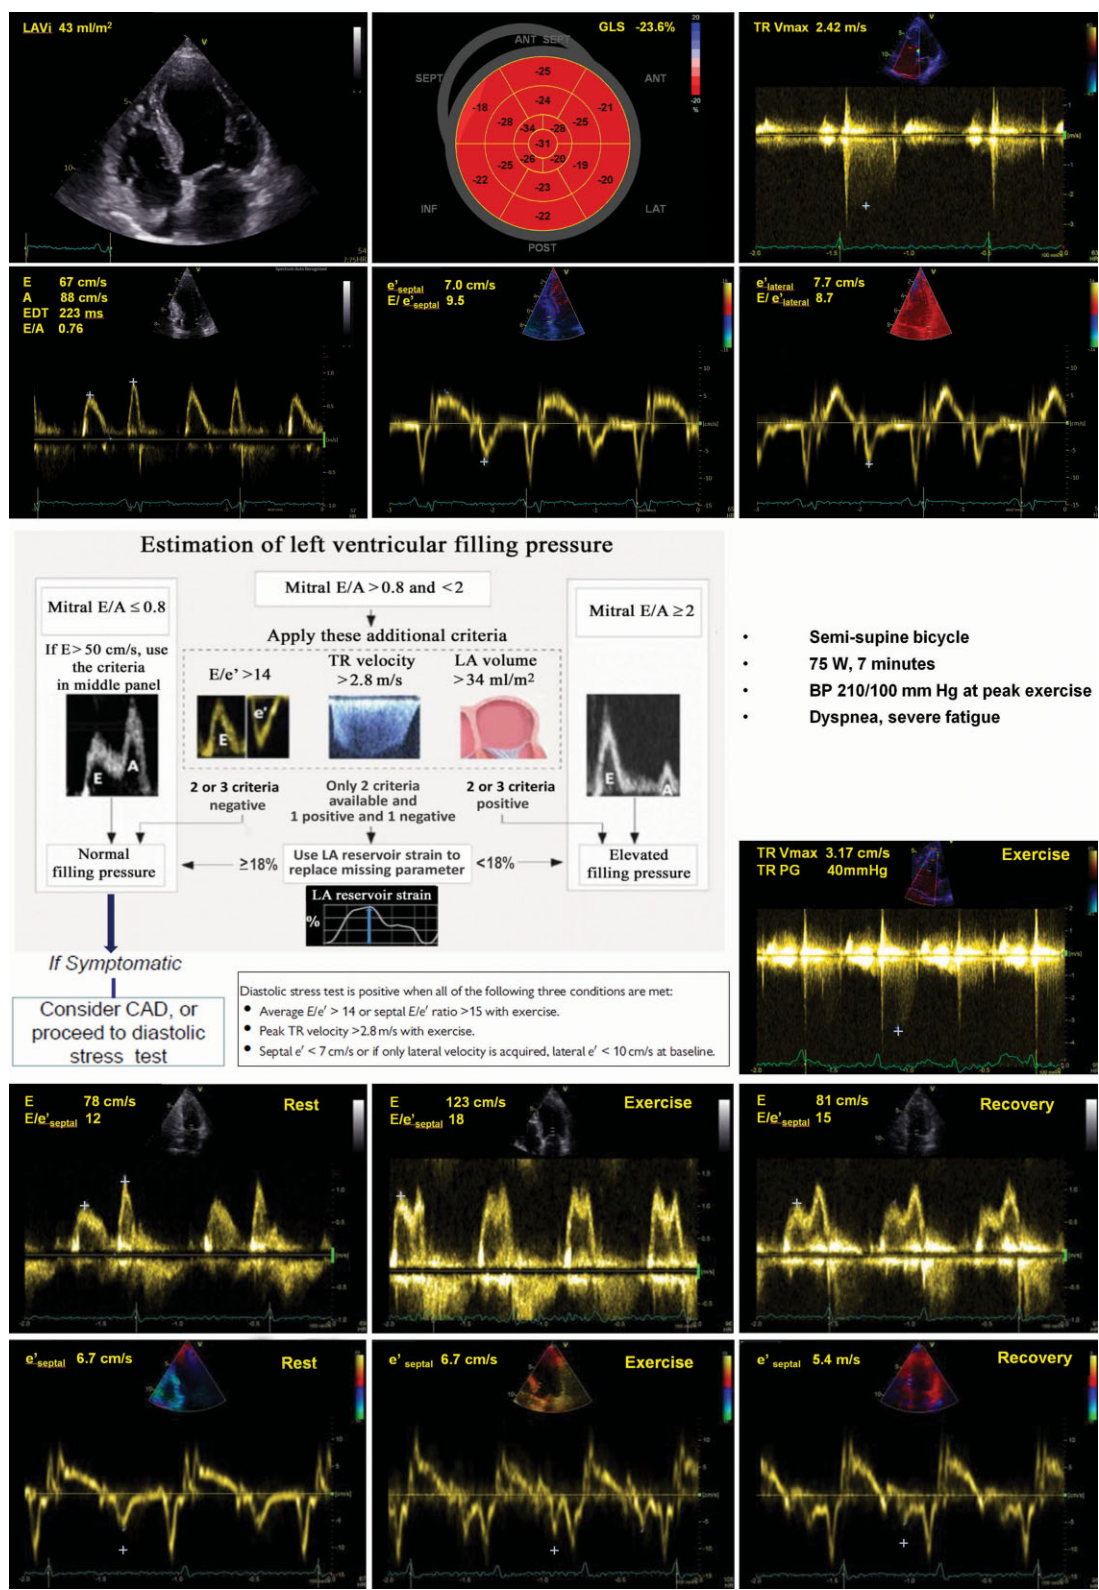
Diastolic stress echocardiographic data acquired at rest, at symptom limited peak exercise and during recovery in a 66-year-old woman with hypertension and exertional dyspnoea. Echocardiographic assessment of left ventricular diastolic function at rest indicates normal left ventricular filling pressure. However, during exercise, there is a significant increase in the E/e' ratio and the tricuspid regurgitation peak velocity, suggestive of elevated left ventricular filling pressure with exercise.
